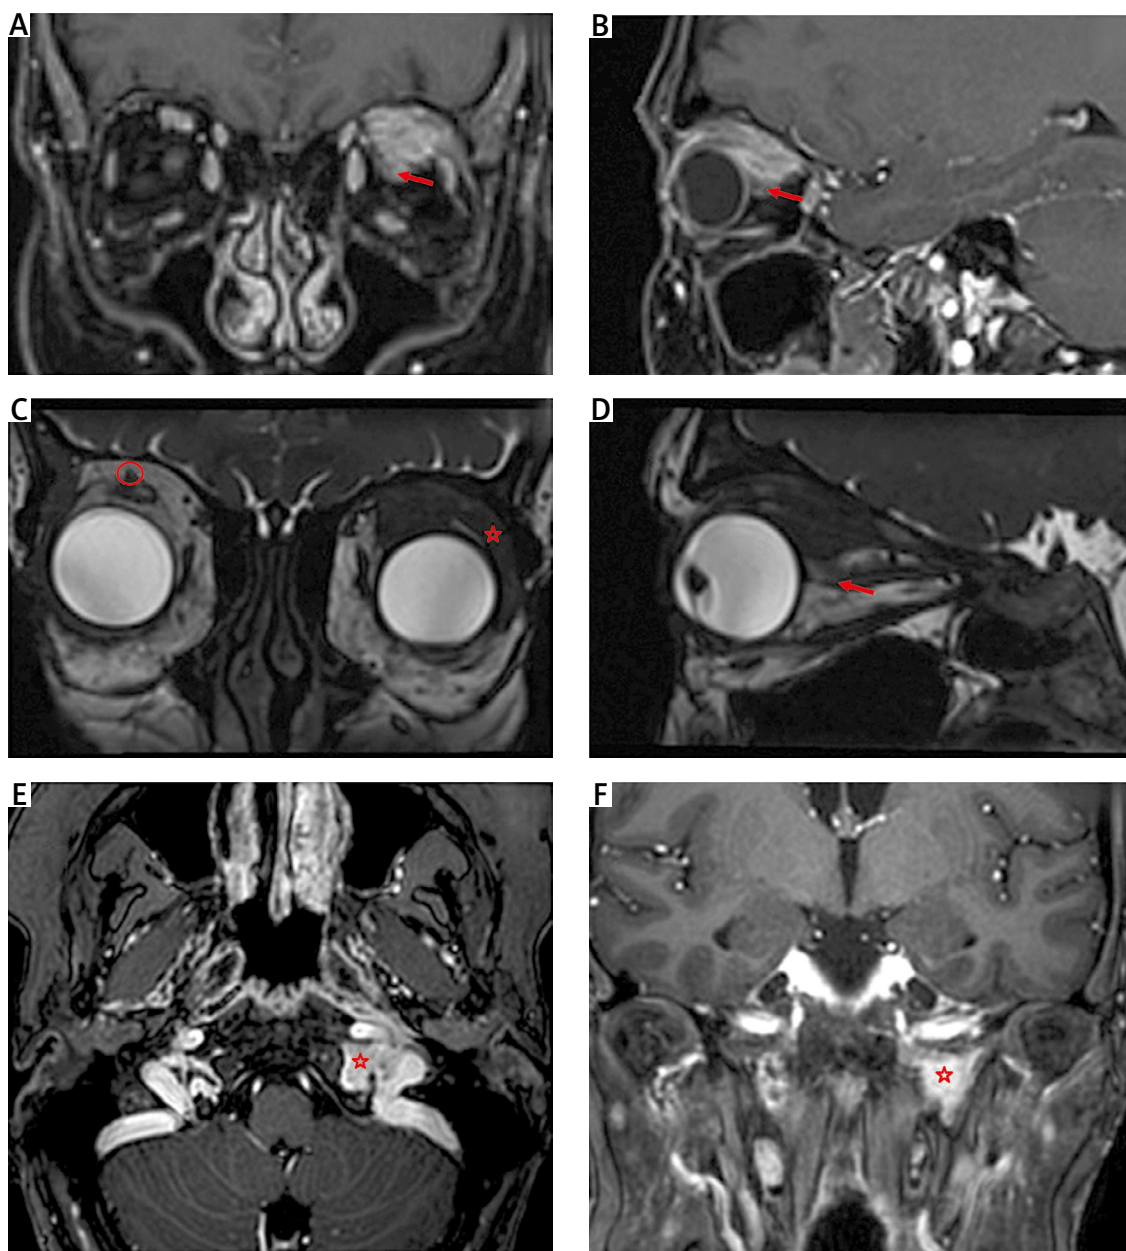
Initial magnetic resonance imaging (MRI) showed a pseudotumorous, infiltrative lesion in the left orbit. The lesion enhanced after contrast administration (arrows in A, B) with infiltration of the lacrimal gland (asterisk in C), lateral rectus muscle, and superior rectus/levator palpebrae muscle complex, along with the supraorbital nerve. The lesion was in close proximity to the globe and the retrobulbar segment of the optic nerve (arrow in D), although these structures were not infiltrated. The supraorbital nerve is marked (circle in C) for reference. A brain MRI revealed a left-sided skull base infiltration at the level of the internal jugular vein foramen (asterisks in E, F) extending into the hypoglossal nerve canal.
